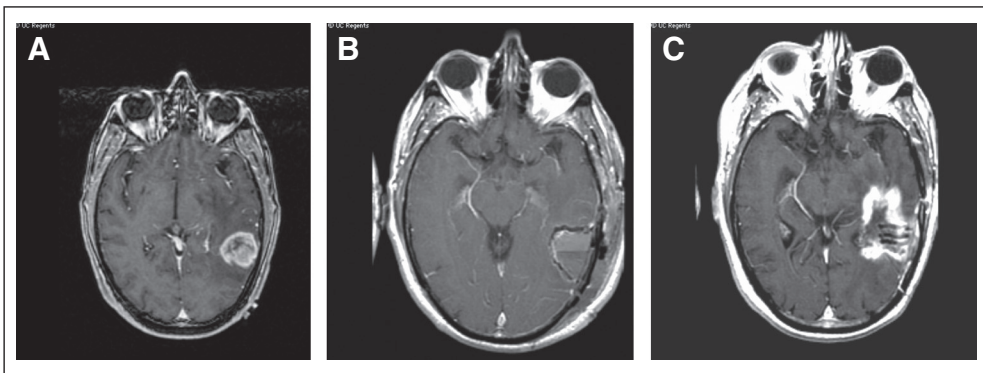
Pseudoprogression after brachytherapy. (A) Axial T1 contrast-enhanced magnetic resonance imaging (MRI) showing enhancing tumor before surgery. (B) Immediate postoperative magnetic resonance imaging (MRI) showing acute surgical changes and placement of iodine-125 brachytherapy seeds. (C) MRI performed 18 months later showing increased enhancement. Reoperation showed no tumor.
